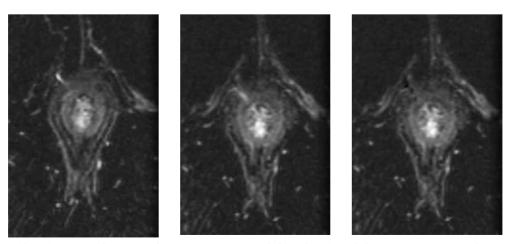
A case of transsphincteric perianal fistula. Axial fat suppression T2 weighted MR imaging showed the high intense fistula tract with mucosal opening at 11 o'clock which completely resolved several months after fibrin glue treatment.
